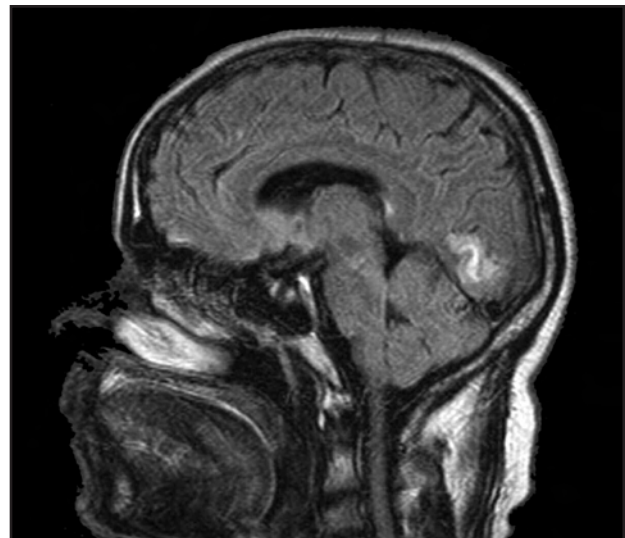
Sagittal MRI scan revealing a right medial occipital lobe lesion involving only the lingual gyrus.
